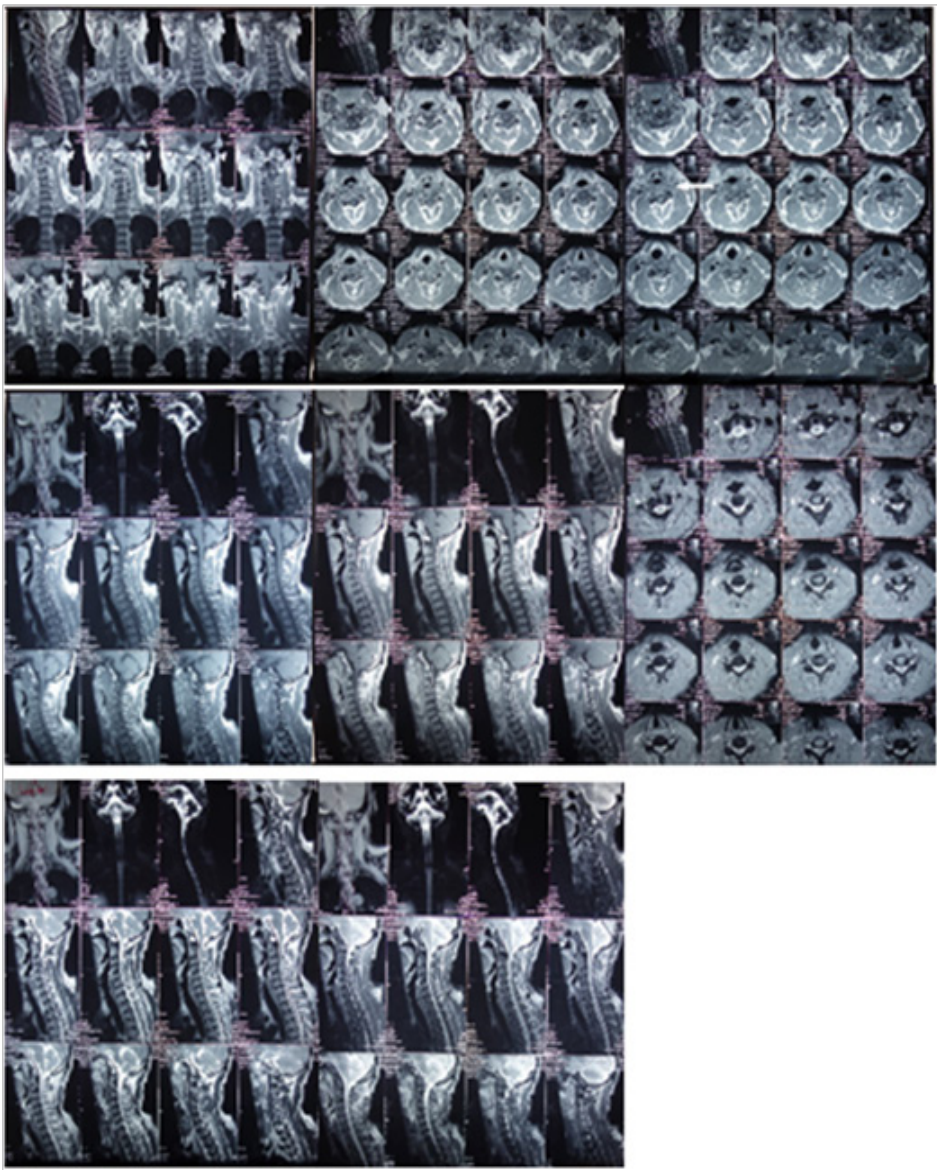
MRI of cervical spine
